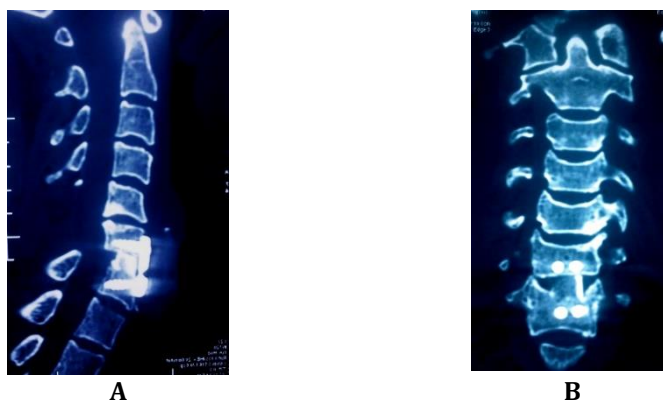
Postoperative CT scan demonstrates good orthopedic results, with anatomical structure restored to normal.
